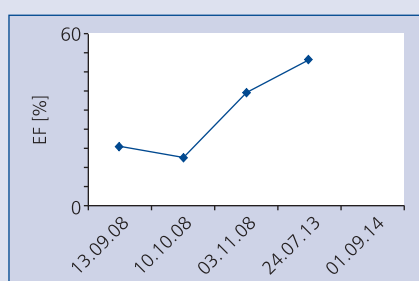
Echocardiographic presentation of ejection fraction (EF%) during and after mechanical device
